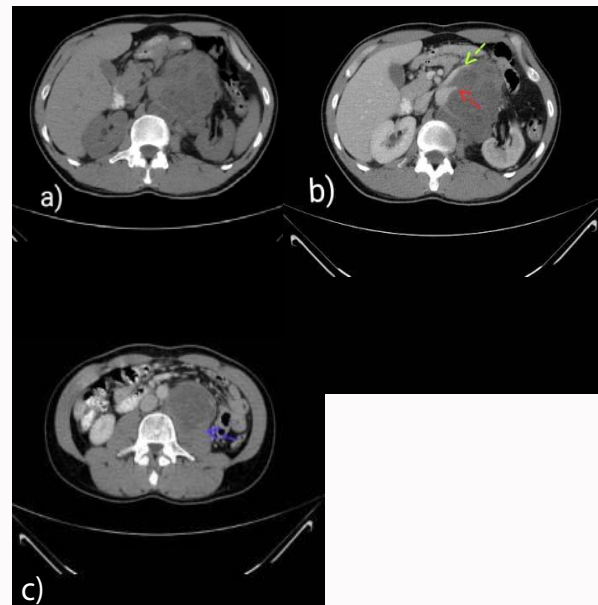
Axial abdomen CT scan pre-contrast (a) and post-contrast (b) show heterogeneous retroperitoneal mass with faint enhancement, the mass is engulfing the left renal artery (red arrow) and left renal vein (green arrow), (c) another section of axial abdomen CT post-contrast showing invading of the mass to the left psoas muscle (blue arrow).
